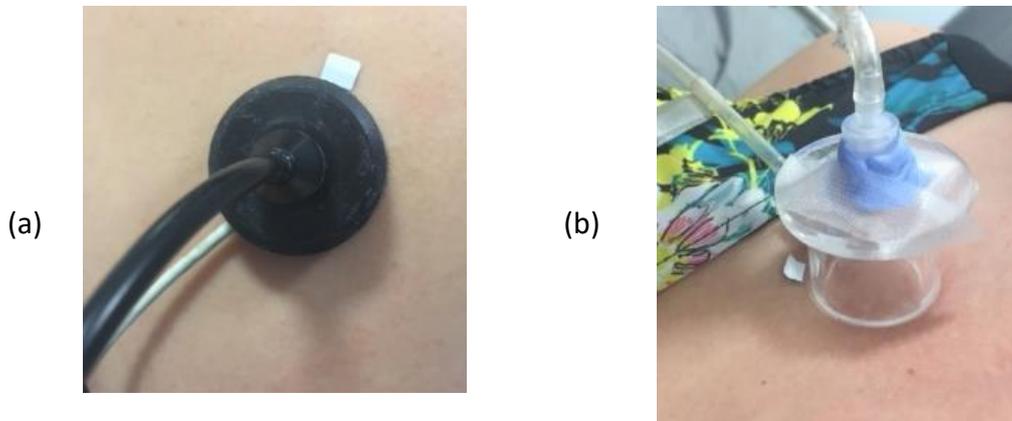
(a) Laser Doppler flowmetry probes fixed with an adhesive heating ring (b) capacitance hygrometry using ventilated capsule technique.
